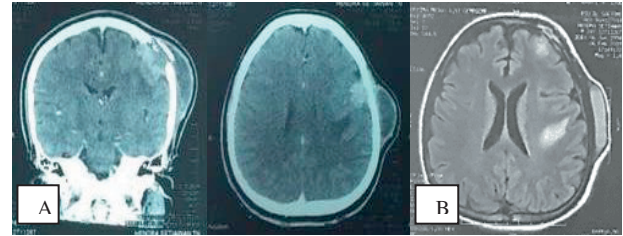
A) Result of head MSCT, B) Head MRI, both showing solid lesions in the left parietal subdural region with *rim contrast enhancement*
